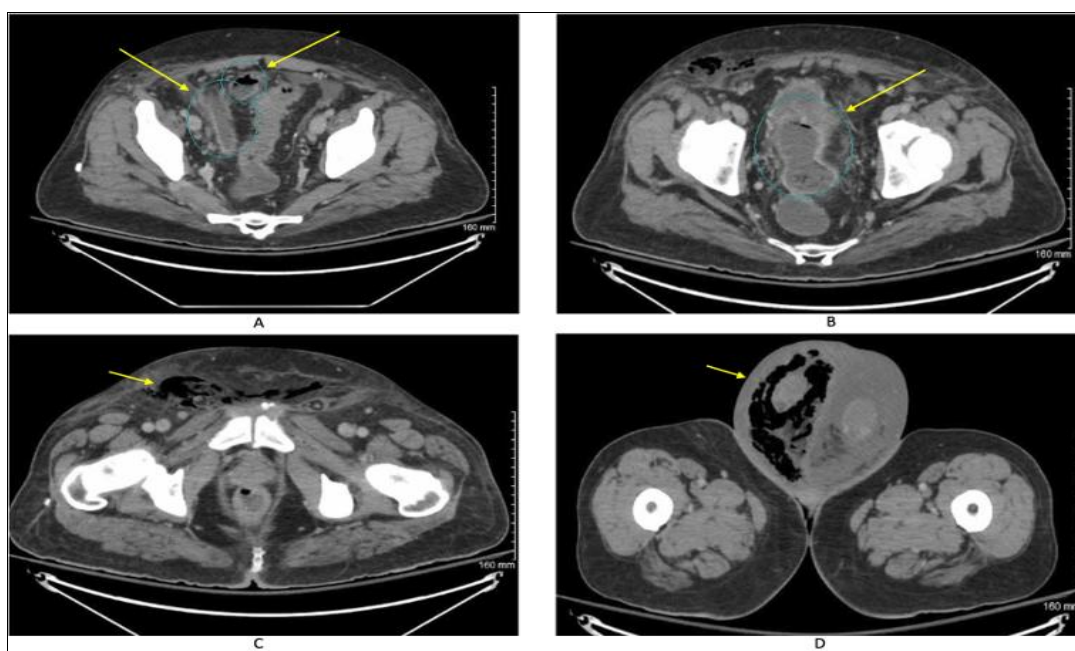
(A-D): (CT A/P axial image; cranial to caudal): Extensive inflammatory changes identified within the pelvis and scrotum. Fluid collections identified within the pelvis which do not definitively correspond with fluid-filled bowel loops, concerning abscess. Gas-forming infection involving the right hemiscrotum and scrotal soft tissues, extending up along the right spermatic cord in the anterior right abdominal soft tissues.
